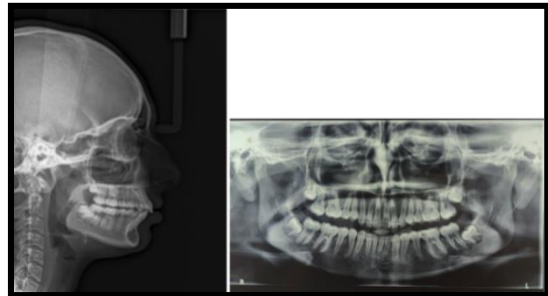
Post-treatment x-rays (a) Lateral cephalogram (b) OPG
